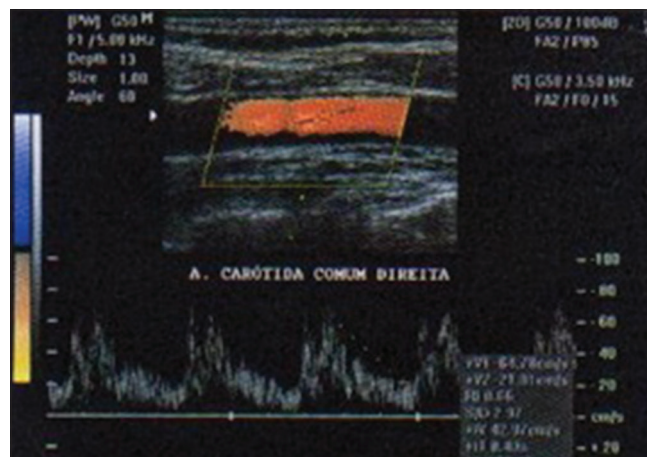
Color Doppler image of the right common carotid artery
